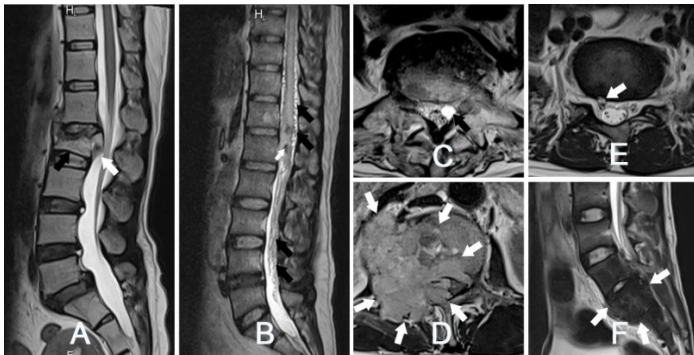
Some common causes of spinal stenosis are uncommon. (a) - Trauma compression fracture at L2 (black arrow) in a 43-year-old female with fragmentation into the spinal canal (white arrow) on a sagittal T2-weighted image. (b) - A 40-year-old man with perimedullary AVF. A sagittal T2-weighted image showed an ill-defined high SI lesion in the T8-10 cord and the tortuous and dilated perimedullary vessels from T8 to L4, suggesting spinal AVF. A ventral dominance of the engorged perimedullary vessels favoured perimedullary AVF and the fistula was suspected to be located near T12-L1, where the flow voids were most crowded (arrowhead). The L1 lumbar arteriography (not demonstrated) revealed the anterior spinal artery being the feeder of a perimedullary AVF and the fistula formation at the level of a lower portion of the T12 vertebral body. (c) - An axial T2-weighted image in 74-year-old female showed an arachnoid cyst in position lateral recess at L5 level. (d) - An axial T2-weighted image 54-year-old man showed a tumour at an L1-L2 level that causes spinal stenosis (arrows). (e) An axial T2-weighted image in 52-year-old man showed a Tarlov of S1 capsule root (arrow). (f) A sagittal T2-weighted image in 24-year-old man showed a tumour in the lumbosacral spine region (pathology diagnosis is osteosarcoma).
